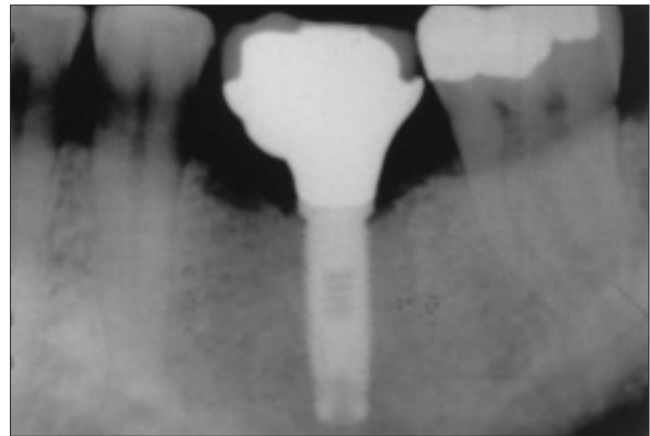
Radiograph of single-implant ceramic crown retained with a metal screw.
